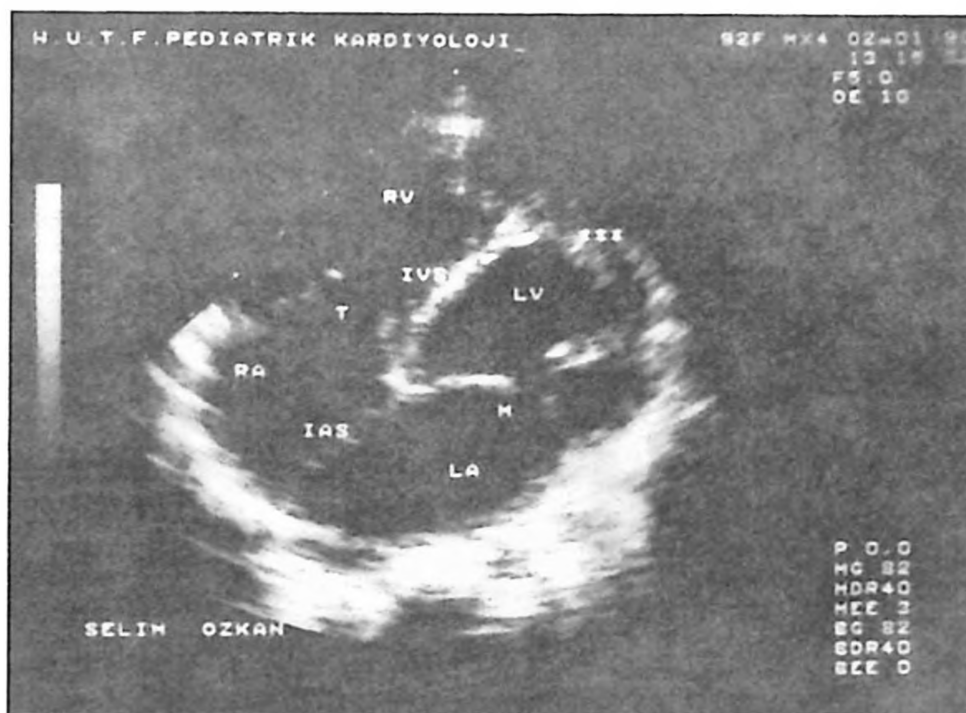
Apical-four chamber view echocardiogram. Obliteration of left ventricular apex is seen (xxx). RV: right ventricle, T: tricuspid valve, RA: right atrium, LV: left ventricle, M: mitral valve, LA: left atrium, IVS: interventricular septum, IAS: interatrial septum.
